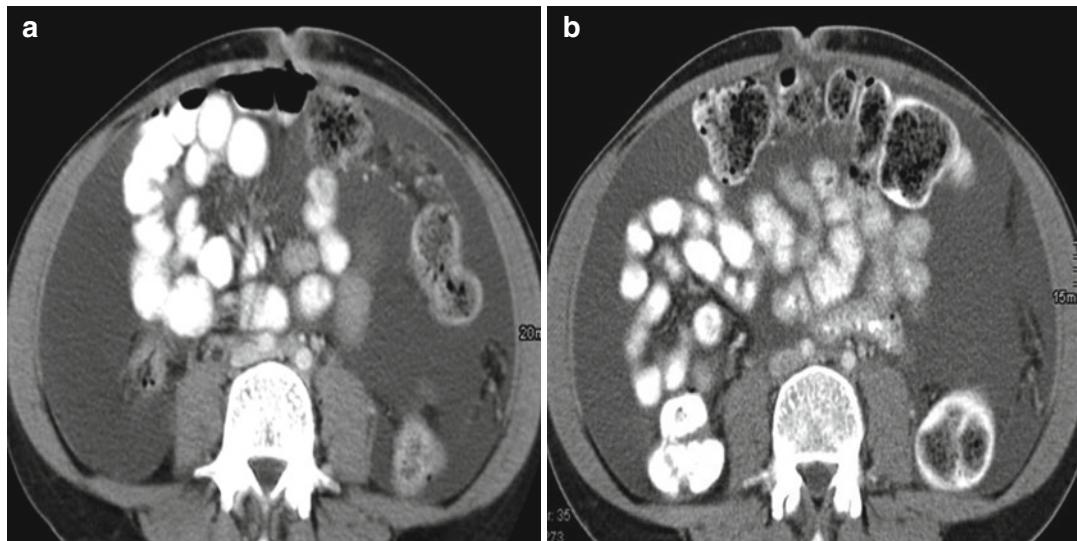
Chylous ascites following laparoscopic lymphadenectomy. CT at the umbilical level in a 27-year-old female with cervical cancer. Large amounts of ascites
